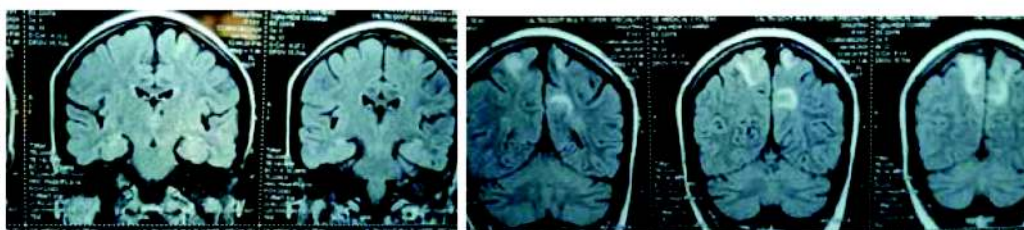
MRI brain FLAIR sequence shows white matter hyperintensity in parieto-occipital region s/o PRES
